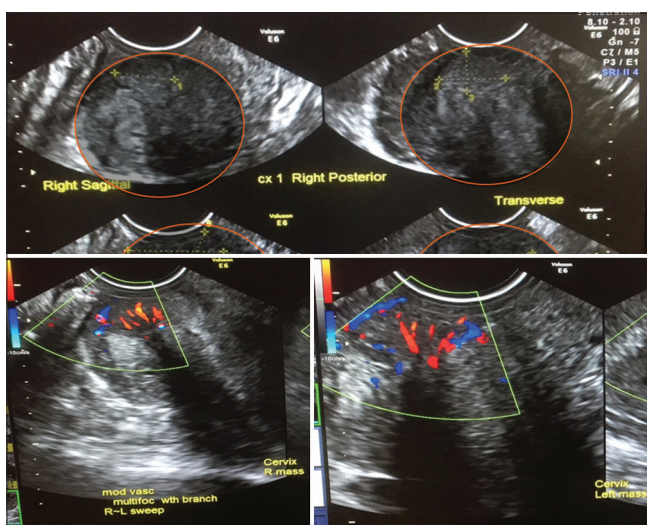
Images of patient's transvaginal ultrasonography with Doppler studies. Impression: Normal-sized uterus with small myomata. Normal secretory endometrium. Normal right ovary with corpus luteum. Normal left ovary with cystic follicle. Cervical masses. Doppler studies: Moderately vascular right cervical mass, probably a cervical tumor. Minimally vascular left cervical mass, probably a polyp
